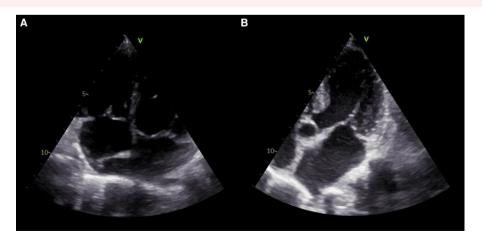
Transthoracic echocardiography at admission, after 1 month of rivaroxaban treatment. (A) Showing an increased size of the right atrium mass. (B) Showing the new occurrence of mitral lesion (arrow showing the vegetation on the anterior leaflet).
